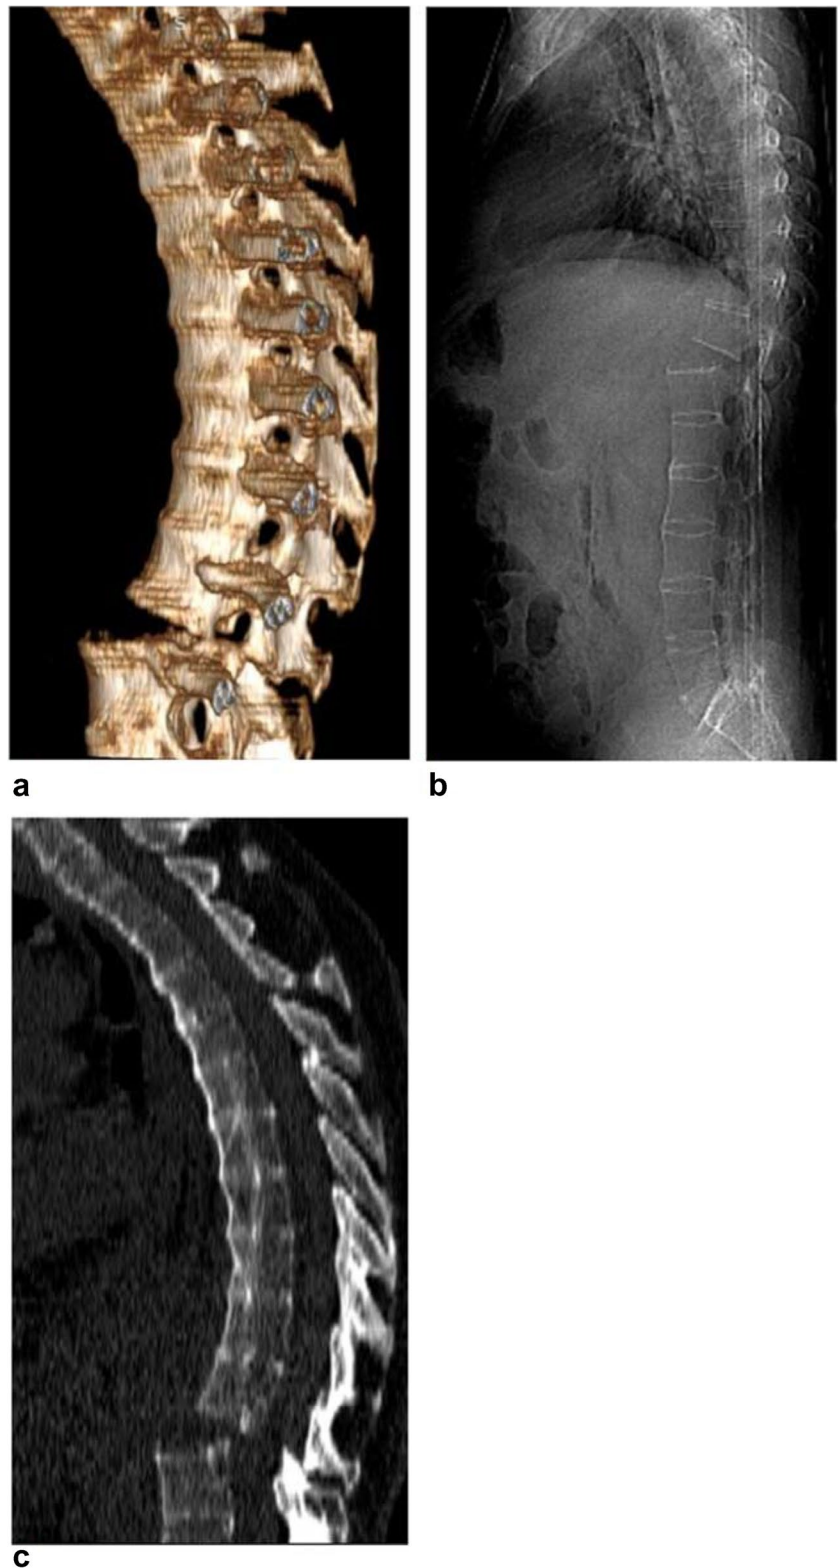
A 68-year-old man with ankylosing spondylitis. a, b, and c Sagittal 3D bone reconstruction (a), CT scout (b), and sagittal CT images (c) (dual-detector CT scanner) of the thoracic spine demonstrate a transdis- cal fracture at T11–T12. The patient choked while eating and sustained the fracture following the Heimlich maneuver
